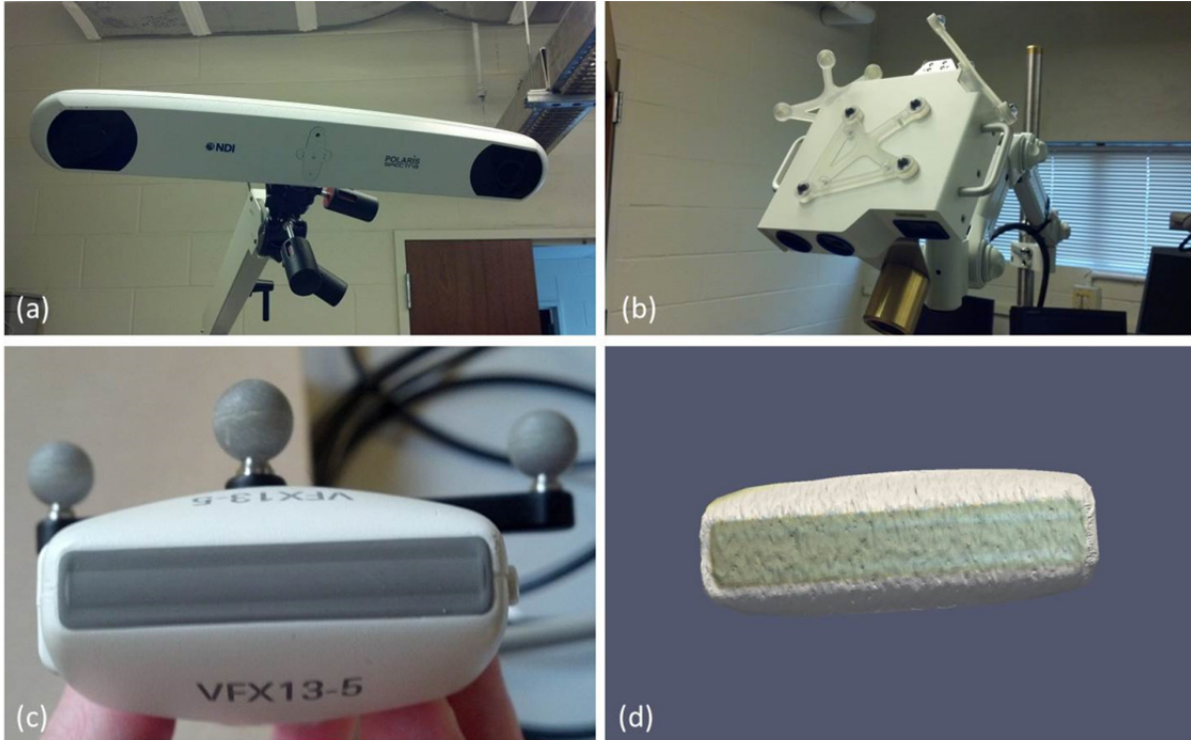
Polaris tracking system (a), and the laser range scanner with passively-tracked targets (b). A passively-tracked target was also used to track the ultrasound probe (c), and the laser range scanner was used to construct a digital representation of the probe surface (d).
